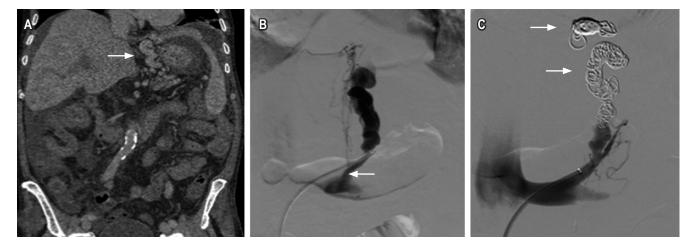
74 year old man. Cirrhosis, gastric varices with gastrorenal shunt. A. Contrast abdominal CT scan shows coronal cut with soft tissue window showing tortuous varices adjacent to the lower curvature of the stomach (arrow). B. Selective venography opacifying tortuous varices in lesser curvature, with some paraspinal drainage veins and gastrorenal shunt (arrow). C. Coil embolization (arrow) occluding the flow in varicose veins.
